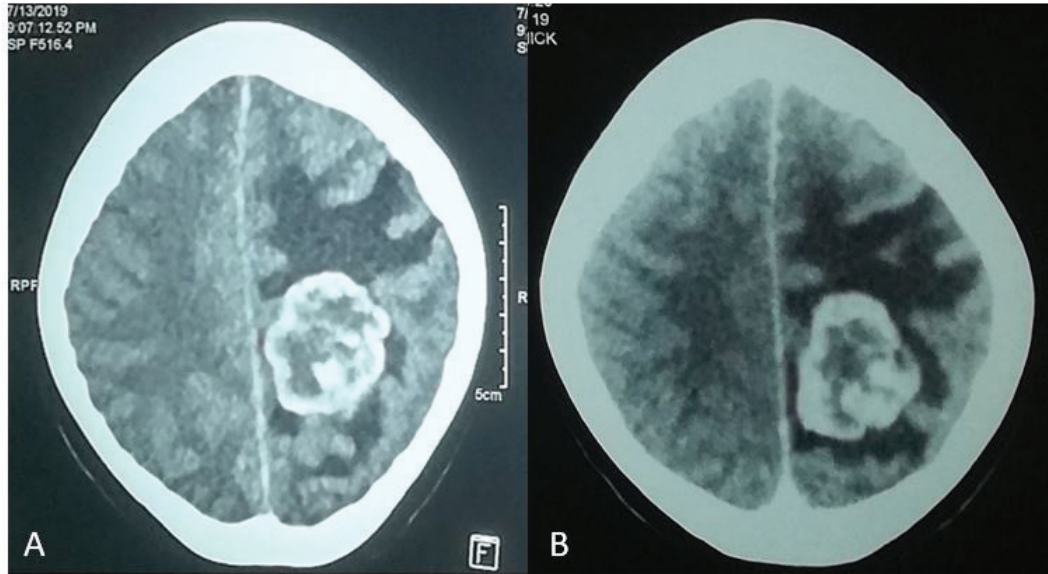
CT head (A: plain; B: Contrast Enhanced) showing likely tumor bleed or cavernous bleed
